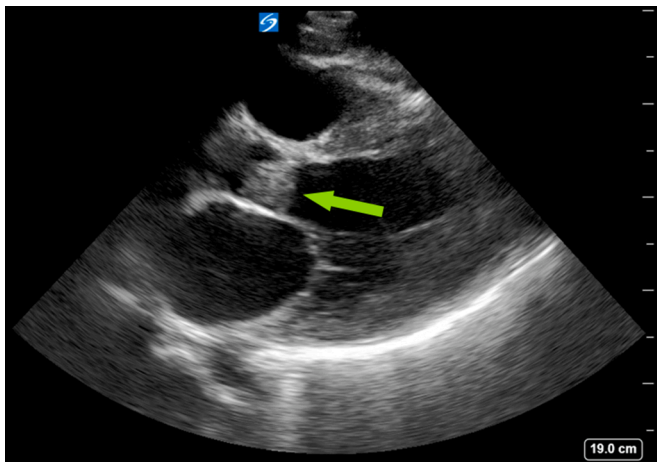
Aortic valve mass in parasternal long.
